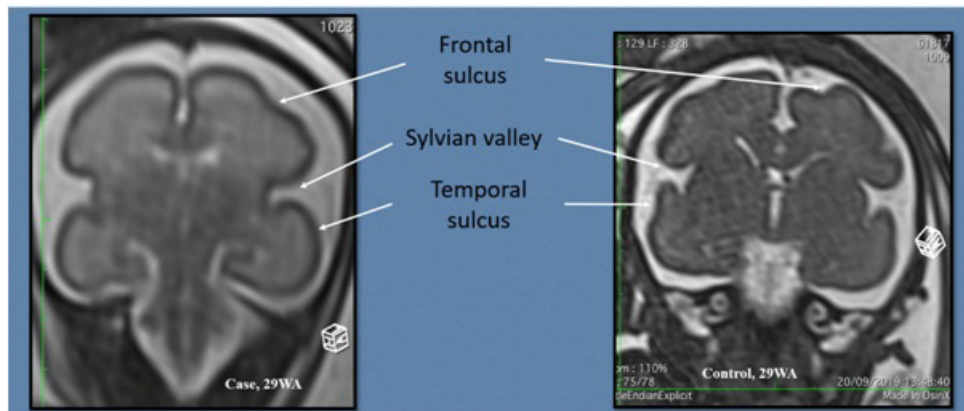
A fetal magnetic resonance imaging showing 2 weeks delayed gyration.
